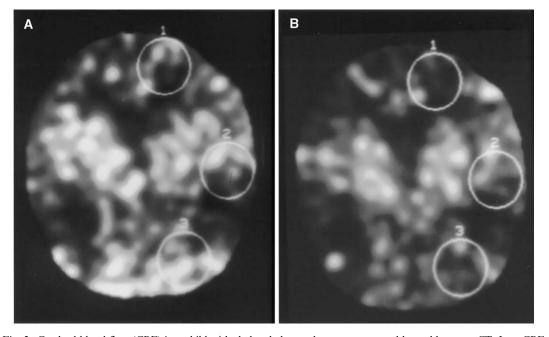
Cerebral blood flow (CBF) in a child with shaken baby syndrome as measured by stable xenon CT. Low CBF (A), particularly in cortical regions of interest, is further reduced by hyperventilation (B).
